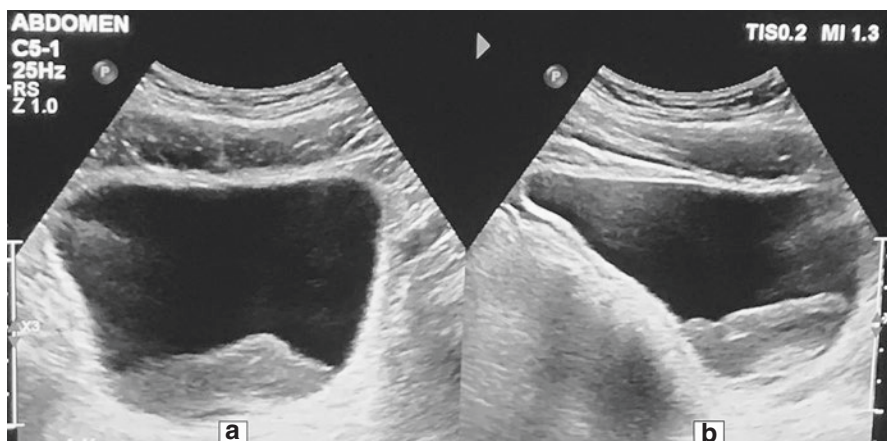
Ultrasonography of urinary bladder showing clots inside the bladder
